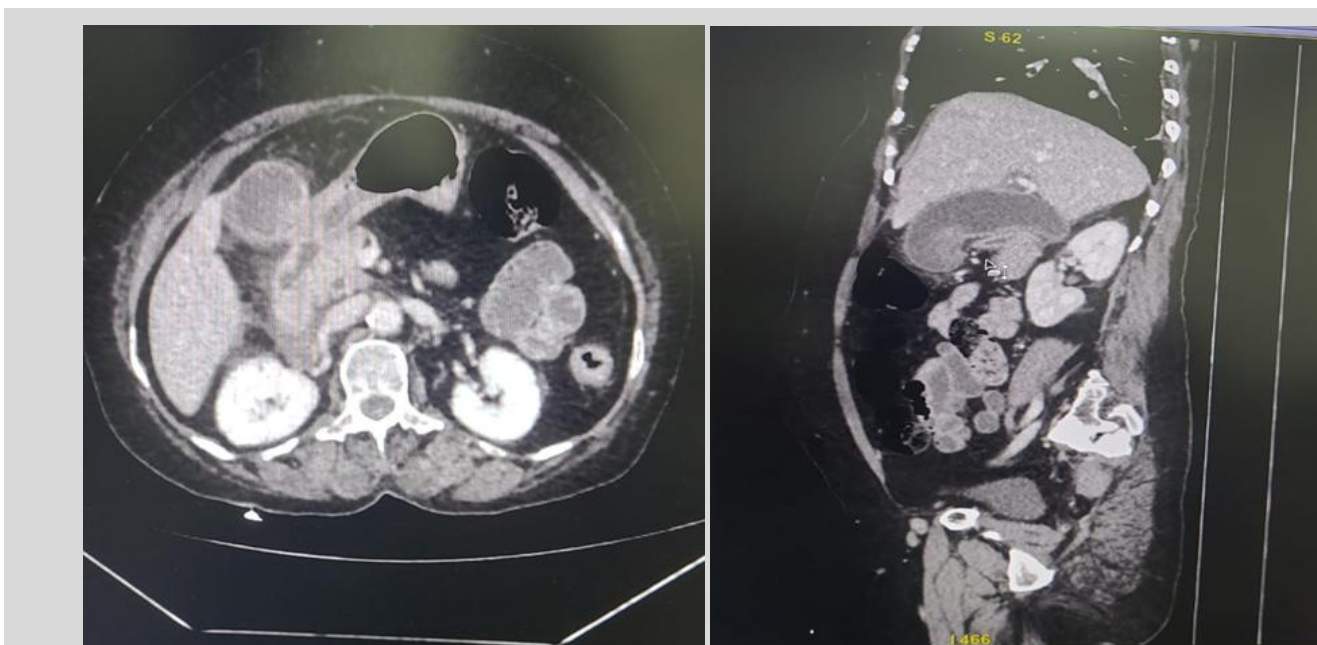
(a&b): CT Impression: Axial CT shows pronounced, irregular gallbladder wall thickening with aggressive infiltration into the liver bed. This finding mandates surgical management as it represents a critical diagnostic challenge, highly suspicious Gallbladder Carcinoma (GBC).
